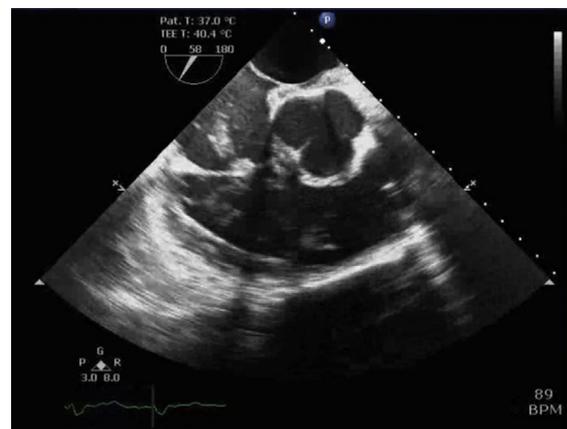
Intraoperative diagnosis of cardiac thrombi by echocardiography during orthotopic liver transplantation. This is an image from intra-operative transesophageal echocardiogram at the midesophageal aortic valve short-axis view with thrombi visualized in the right atrium and right ventricle.
